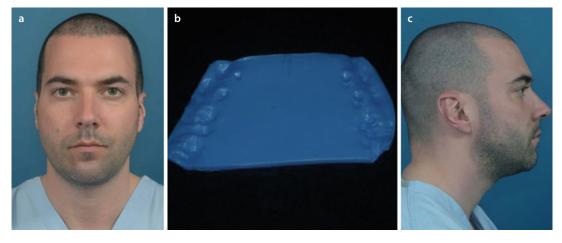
A wax-bite wafer (Delar Corp., Lake Oswego, USA) was taken in CR as in conventional treatment planning to ensure adequate CR during CBCT scanning (b). Note the significant distortion of the lips and the cheeks when the wax-bite wafer is not trimmed (a, c) (volunteer M.G.)
